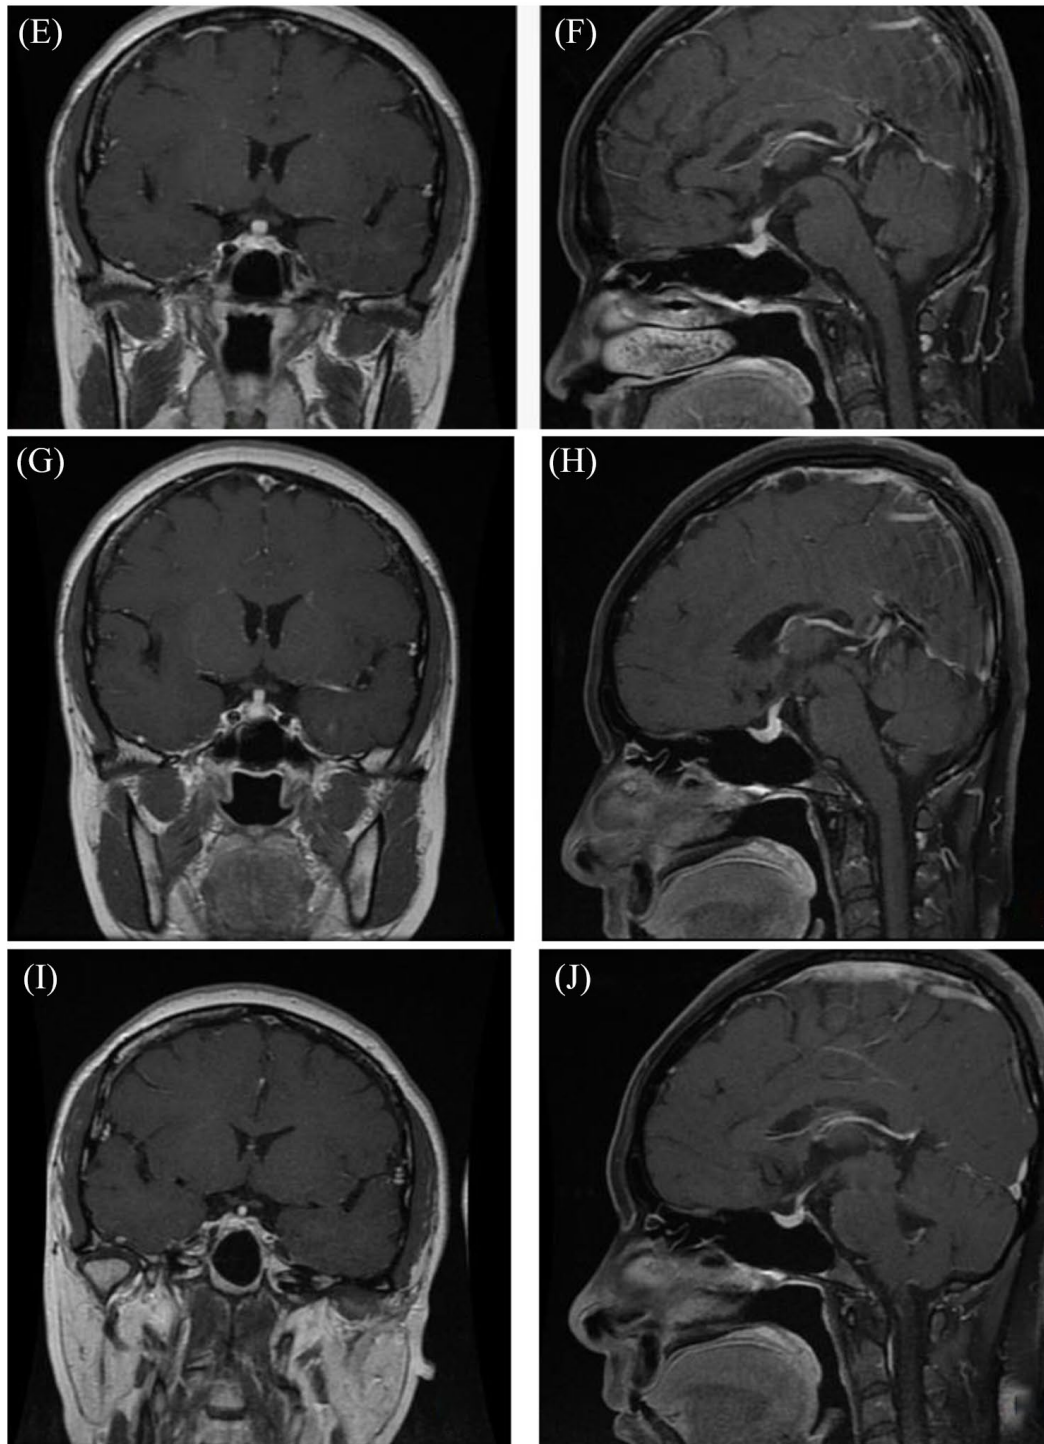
Pituitary MRI for case 2 (female, 43years old). (E) and (F) show thickening of the upper part of pituitary stalk and loss of the posterior pituitary signal on T1 MRI (December 2018). (G) and (H) show a thinner pituitary stalk 2 weeks after glucocorticoid treatment (11 February 2019). (I) and (J) show that the pituitary stalk recovered to normal 3 months after glucocorticoid treatment (13 May 2019). MRI, magnetic resonance imaging.
